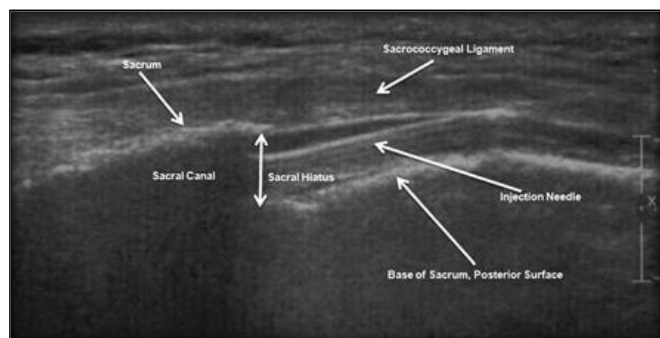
Ultrasound Identification of Sacral Hiatus and Caudal Epidural Space
